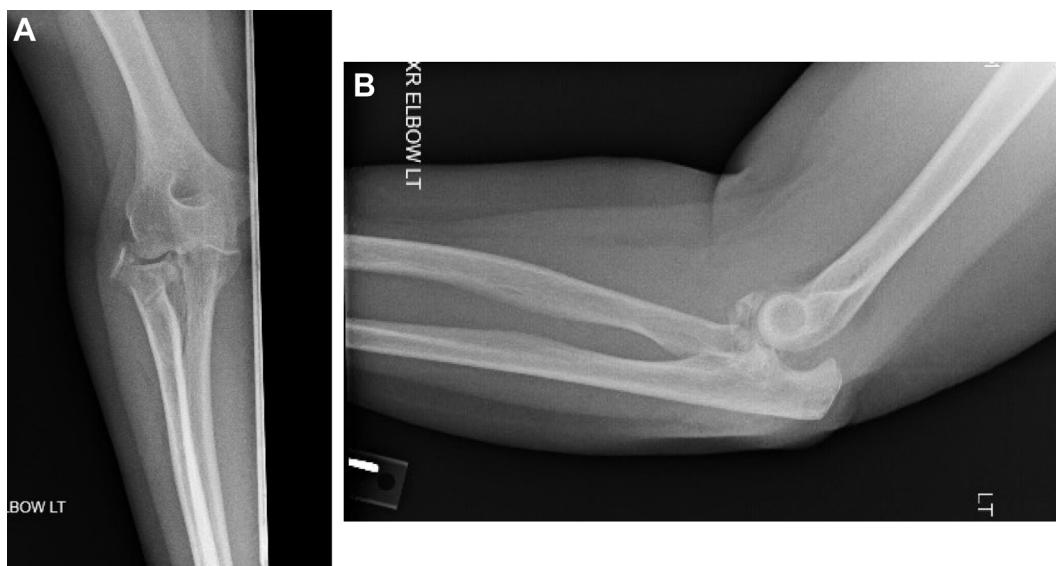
Case 6: A 56-year-old right-handed woman sustained a ground level fall. Radiographs revealed left elbow dislocation with displaced radial head fracture, coronoid fracture, and olecranon fracture (see Figs. 19 and 20). She underwent ORIF of left coronoid, left olecranon, left radial head, and lateral ulnar collateral ligament repair (see Fig. 21). At 5-month follow-up, she achieved ROM of 10° to 138°, 70° supination, and 90° pronation with no pain.
